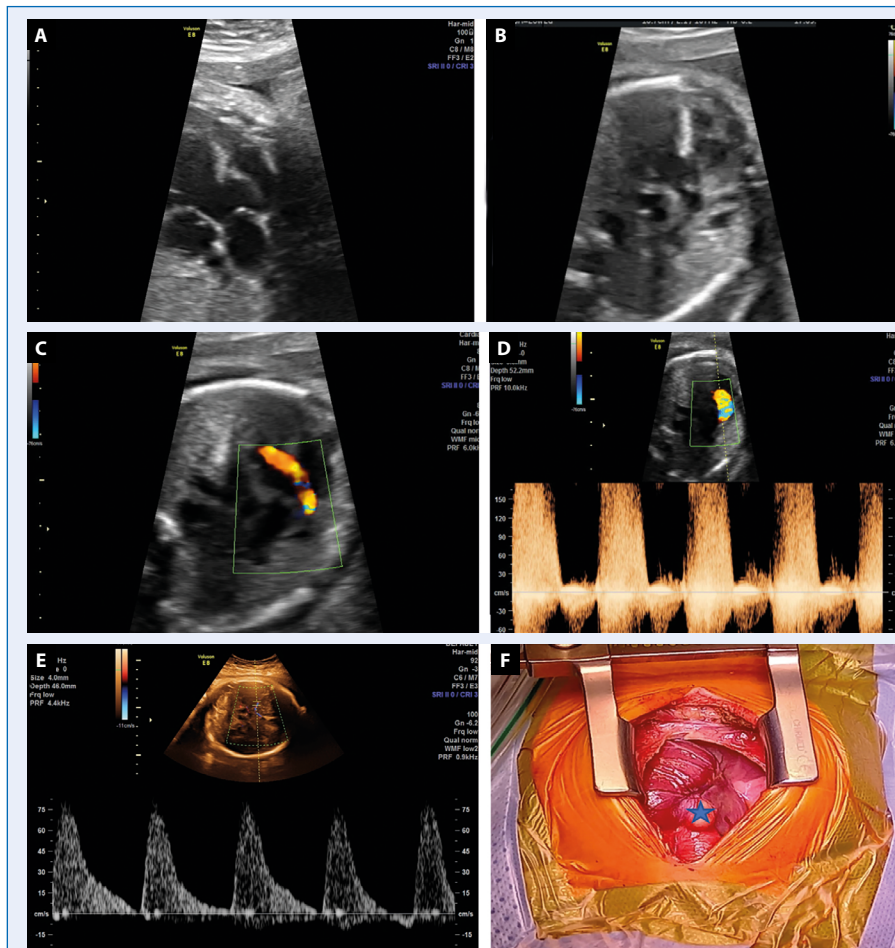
A. Aorto-left ventricular tunnel (ALVT) in gray scale; B. AVLT in gray scale; C. AVLT in color Doppler; D. Retrograde flow in AVLT; E. Middle cerebral arterial (MCA) peak systolic velocity (PSV); F. Visualization AVLT during operation
